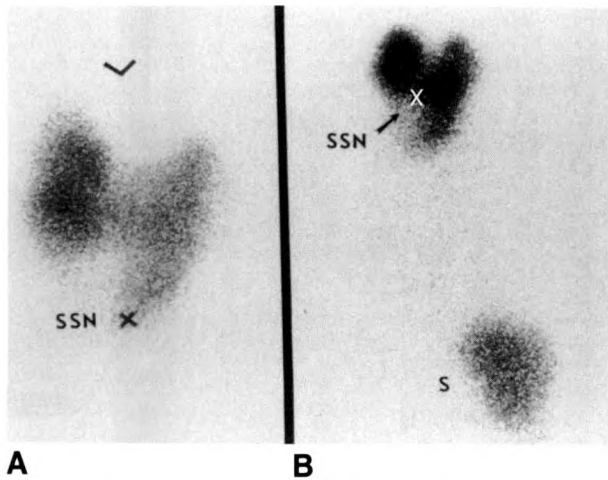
Parallax error of pinhole scintigraphy. X shows suprasternal notch (SSN).
